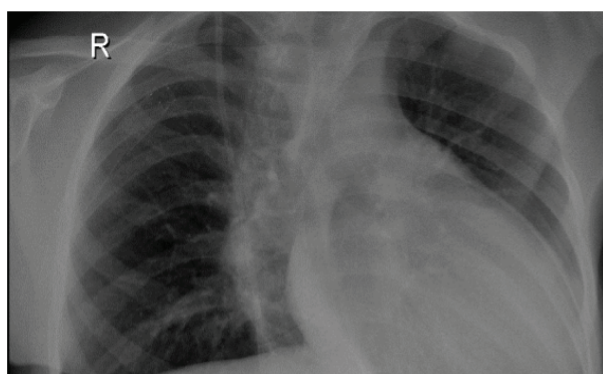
Chest X-ray Revealing No Further Migration of the Stents
